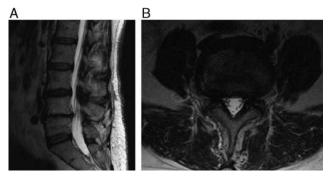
Case 2: Preoperative magnetic resonance imaging; (A) sagittal view showing L4–5 herniated disk, L4–5 spinal stenosis, L4–5 disk collapse and end plate edema; (B) axial view showing L4–5 spinal stenosis.
